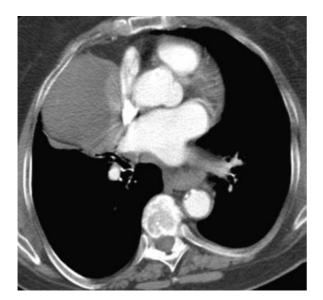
Axial chest CT with contrast demonstrates a large solid/cystic mass in the right chest adjacent to the superior vena cava and right pulmonary artery. This was described as being confined to the pericardial fat. Note the contrast is in the superior vena cava, aorta, and pulmonary arteries and does not fill the lesion in the right chest.
